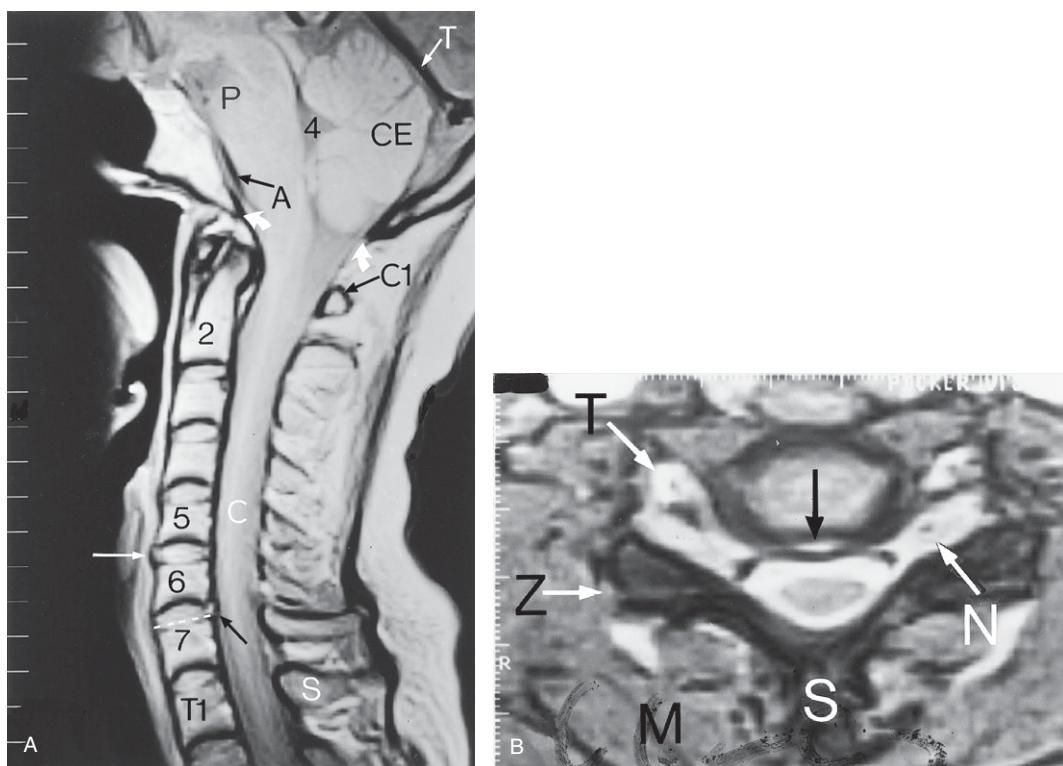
(A) Cervical spine MRI sagittal T1-weighted image showing the small posterior disc protrusion at the C6–7 disc (black arrow) and the anterior disc bulge at C5–6 (white arrow). 2 = body of the second cervical vertebra; 5, 6 and 7 show the bodies of the fifth, sixth and seventh cervical vertebrae; T1 = body of first thoracic vertebra; C = spinal cord; S = spinous process of T1 vertebra; C1 = posterior tubercle of the first cervical vertebra; CE = cerebellum; 4 = fourth ventricle; P = pons; T = tentorium cerebelli; A = basilar artery; curved white arrows show the anterior (clivus) and the posterior (or occiput) margins of the foramen magnum. The approximate level for the axial scan shown in (B) is represented by the white broken line that gives the plane of the axial section. (B) MRI axial T2-weighted image at the C6–7 level (see A). M = muscles adjacent to the spinous process (S); T = transverse foramen (containing the vertebral artery, vertebral vein and the sympathetic plexus on the vertebral artery); Z = zygapophysial joint with superior and inferior articular facets opposite each other; N = nerve root ganglion in the left intervertebral foramen; black arrow shows the disc protrusion posterior to the C6–7 intervertebral disc.
